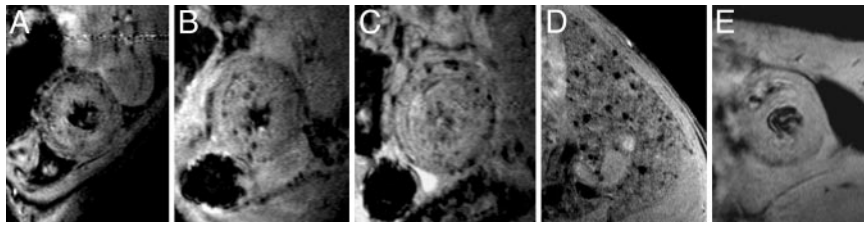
In vivo* MRI of allograft hearts and lungs, 1 day after i.v. injection of MPIO particles. (A) Allograft heart on POD 5. (B and C) Allograft heart on POD 6. (D) Allograft lung on POD 6. (E) Isograft heart on POD 6. Shown with 156- μ m in-plane resolution at 4.7 Tesla by using a Bruker Biospec AVANCE-DBX MRI instrument.
